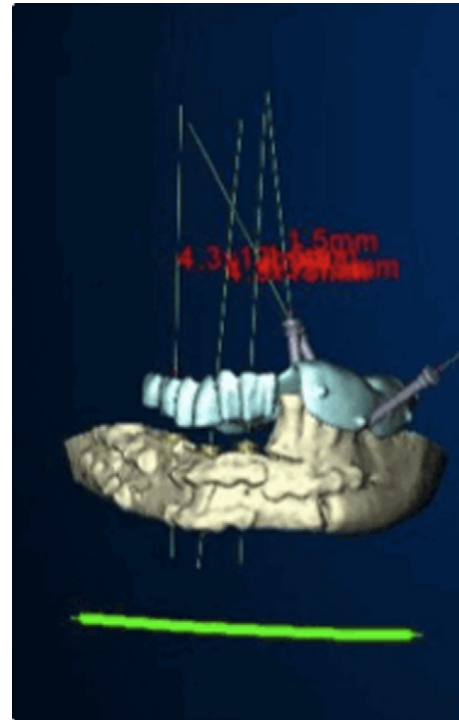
Three-dimensional computed tomographic virtual implant planning in a fibular free flap.
